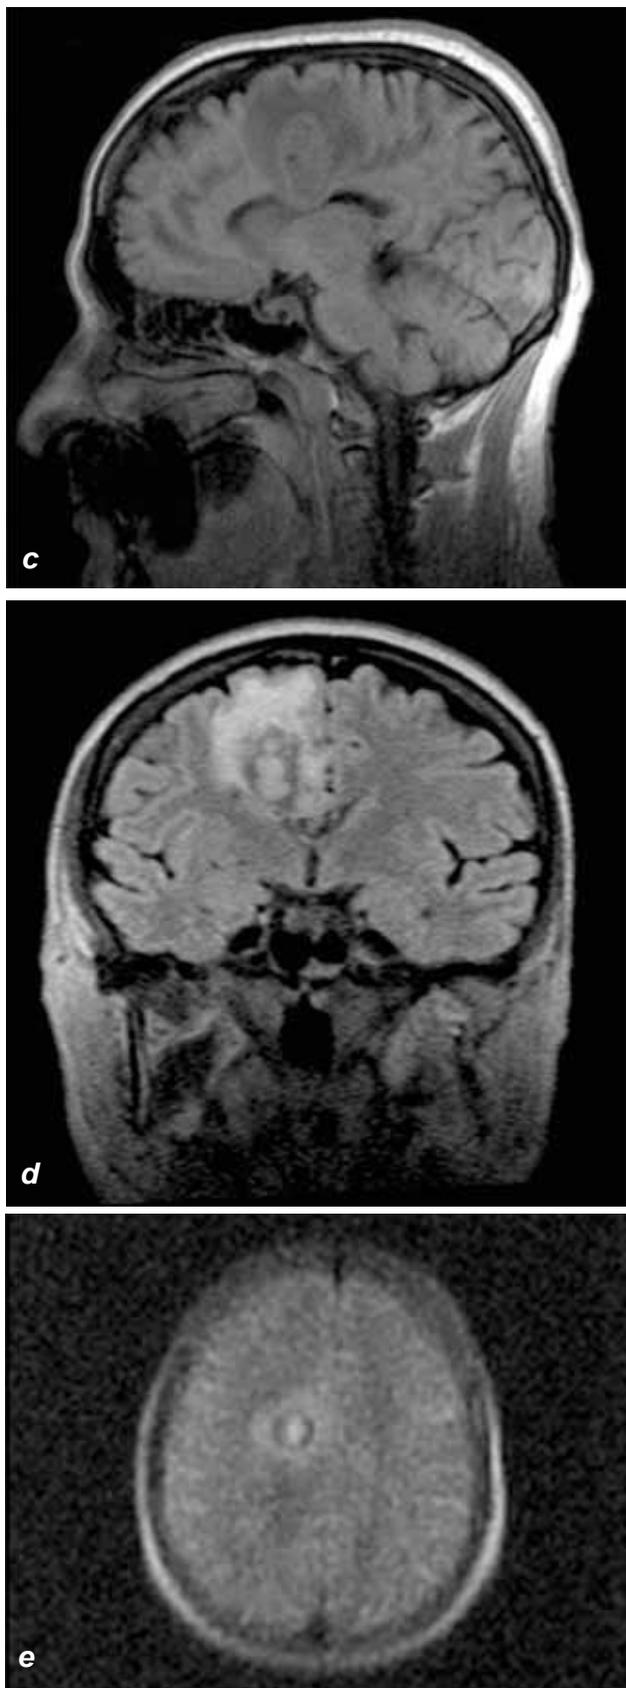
c. Sagittal T1-weighted image (T1W) shows isointense to hypointense lesion in the right frontal lobe with surrounding moderate vasogenic edema. d. Coronal FLAIR sequence – hyperintense center with hypo/isointense halo and surrounding edema. e. Diffusion weighted imaging (DWI) shows slight hyperintensity in the right frontal lobe.
